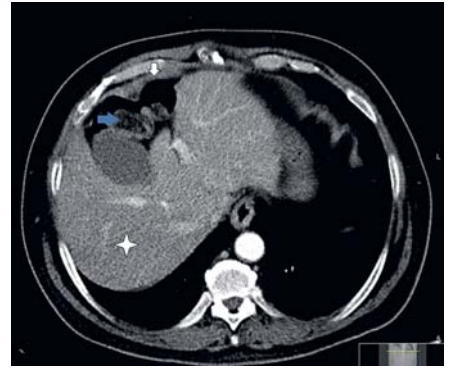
Coronal view of abdominal computed tomography scan with evidence of Chilaiditi sign (white arrow, right hemidiaphragm; blue arrow, colon; asterisk, liver).
